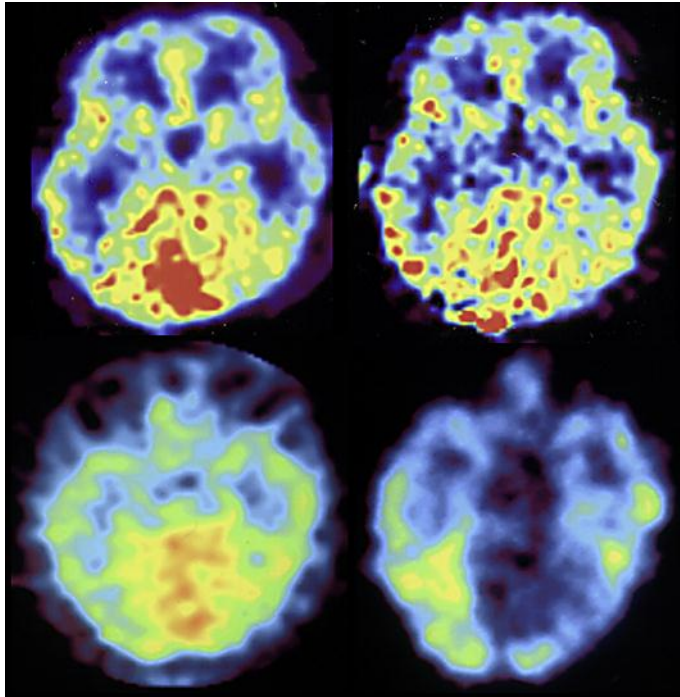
The cerebellar lesion exhibited a hyperperfusion on blood flow imaging (upper left) and a hypermetabolism on the metabolic rate of oxygen imaging (upper right), respectively, on ^{15}O -gas PET. $^{99\text{m}}\text{Tc}$ -ECD (lower left) and ^{123}I -iomazenil (lower right) SPECT show hyperactivity and a defect in the uptake of the lesion.
